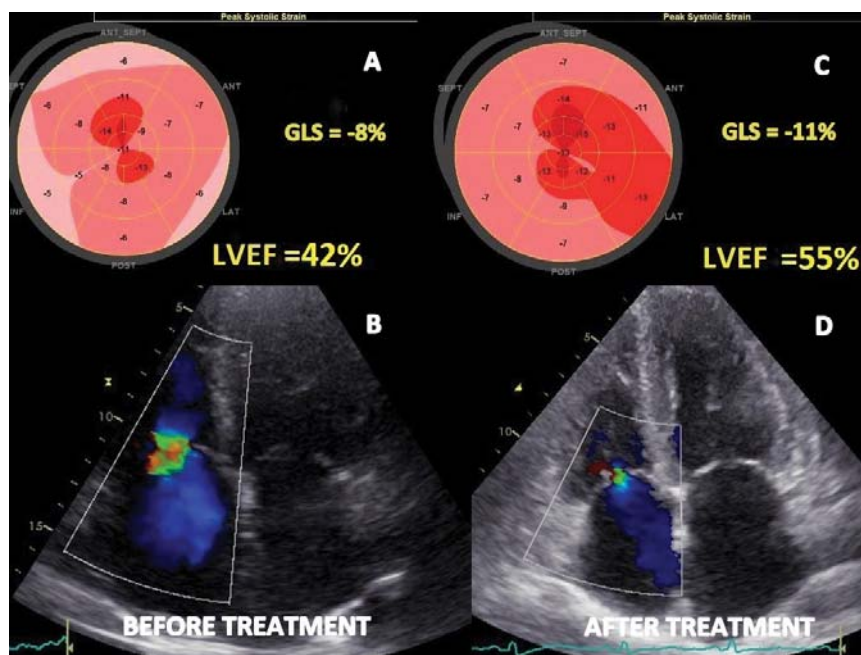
Transthoracic echocardiographic images before and after chemotherapy and stem cell transplantation. A and B (before treatment) images. A: Bull's eye plot image showing significantly reduced GLS (-8.4 %) with severe altered deformation mainly at the basal and midventricular segments and relatively preserved at the apex, with a typical apical sparing strain pattern or „cherry-on-top” pattern. B: severe tricuspid regurgitation on Colour Doppler images. C and D (after treatment) images. C: Bull's eye plot image showing an improvement in GLS (-11%) predominantly on the lateral and anterior wall. D: significantly regression of tricuspid regurgitation to mild by Colour Doppler images. GLS: global longitudinal strain.
